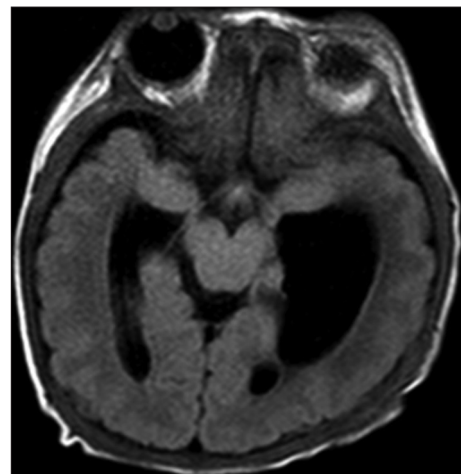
Brain T2 fluid-attenuated inversion recovery magnetic resonance imaging image revealing trapped temporal horn of the left lateral ventricle
